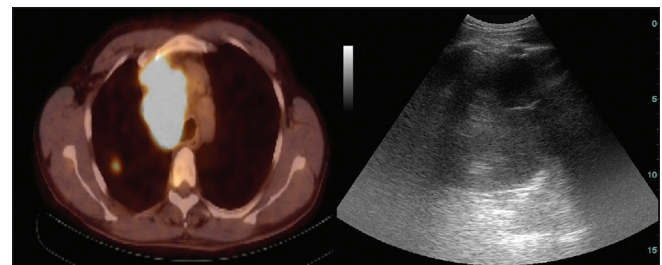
On the left, on positron emission tomography-computed tomography, hypermetabolic lesion compatible with the mediastinal mass lesion. Ultrasonographically in approximate dimensions of 6 cm × 5 cm, irregular margin hypoechoic lesion
